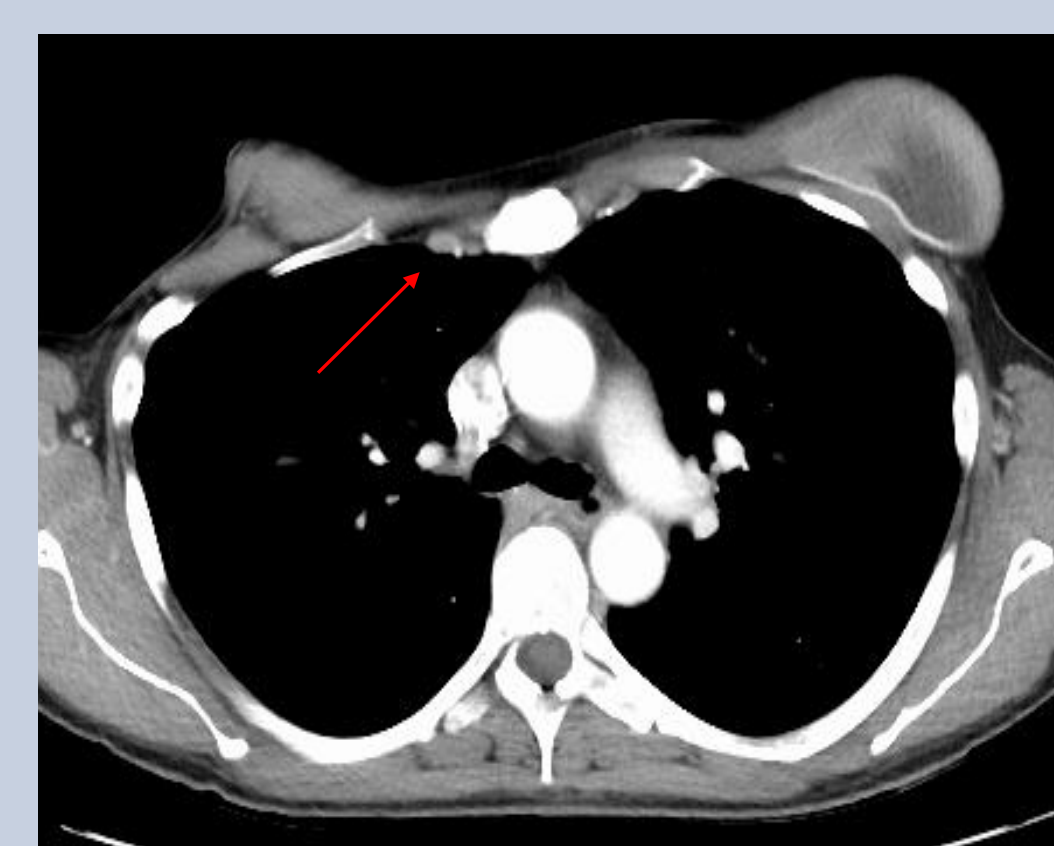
Axial CT demonstrating an enlarged right internal mammary lymph node
